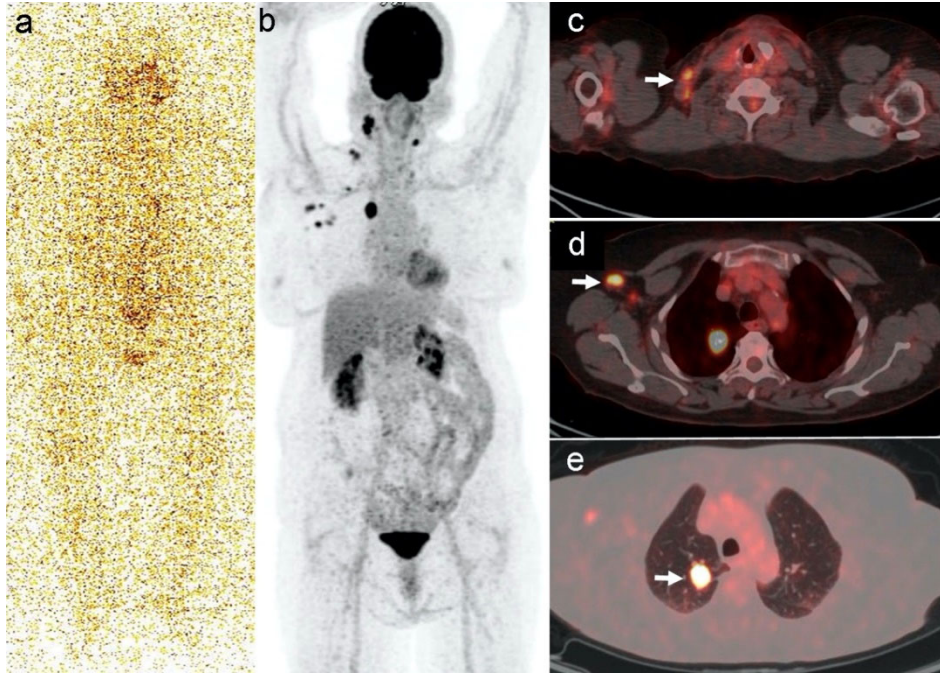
Negative diagnostic whole-body ^{131}I planar anterior image (a), ^{18}F -FDG PET/CT Maximum Intensity Projection (MIP) image (b) and fused axial images showing tracer avid bilateral cervical, right supraclavicular and right axillary lymph nodes, and right lung nodule (c-e; arrows)
